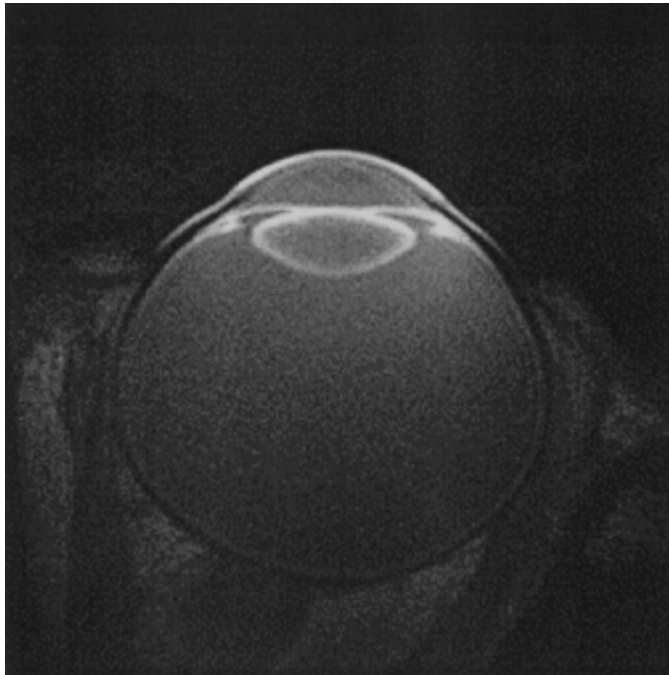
T1-weighted MR image of the right open eye of a 42 year old subject using a customised eye imaging radio frequency coil and 1.5 Tesla external magnetic field (Koretz et al., 2004).
